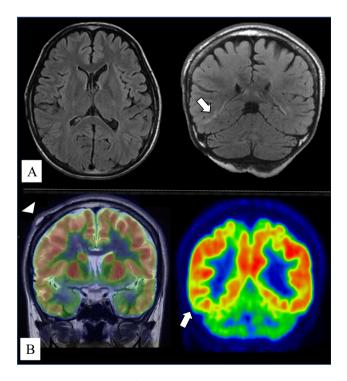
Representative MR and ¹⁸F-FDG PET images. A: MR images (FLAIR axial and coronal) show an abnormal hyperintense signal (arrow) extending from the ventricle to the cortex in the right posterior-temporal lobe. No other abnormalities (including cerebral infarction) are seen, and cerebral perfusion appears to have remained normal. B: Images from ¹⁸F-FDG PET show hypometabolism in the right temporal lobe (arrow), corresponding to the focal lesion on MRI. No abnormal metabolism is seen in other areas, including the vicinity of the shunt catheter (arrowhead).
